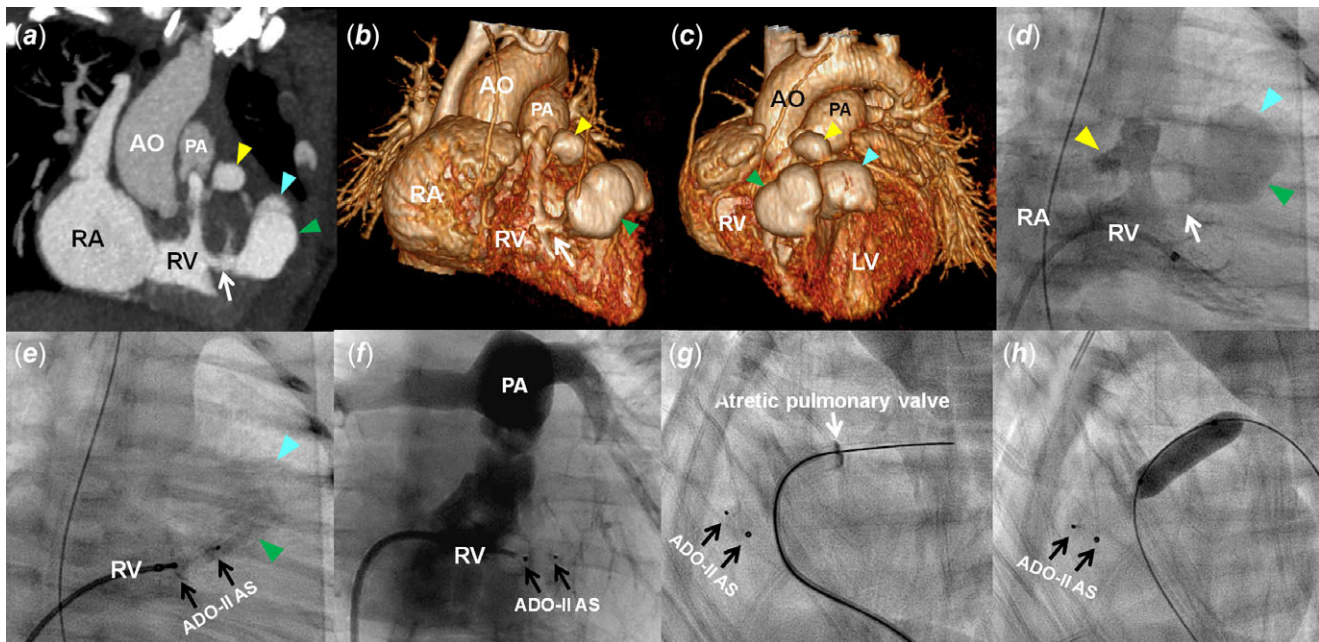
Images of CT and interventional catheterisation. (a–d) Cardiac CT and right ventriculography showed three false aneurysm sacs (arrow heads). The two large aneurysms appeared as one lesion with two lobes (white arrows). (e and f) RVG showed an ADO-II AS (black arrows) that was placed in the narrow neck with a good position, and aneurysms regressed totally 8 months later. (g) Perforation of the atretic valve by the coronary guidewire. (h) A 6 mm Tyshak II Balloon was used for pulmonary valvuloplasty. ADO-II AS = Amplatzer Duct Occluder II Additional Sizes; AO = aorta; PA = pulmonary artery; RA = right atrium; RV = right ventricle.
